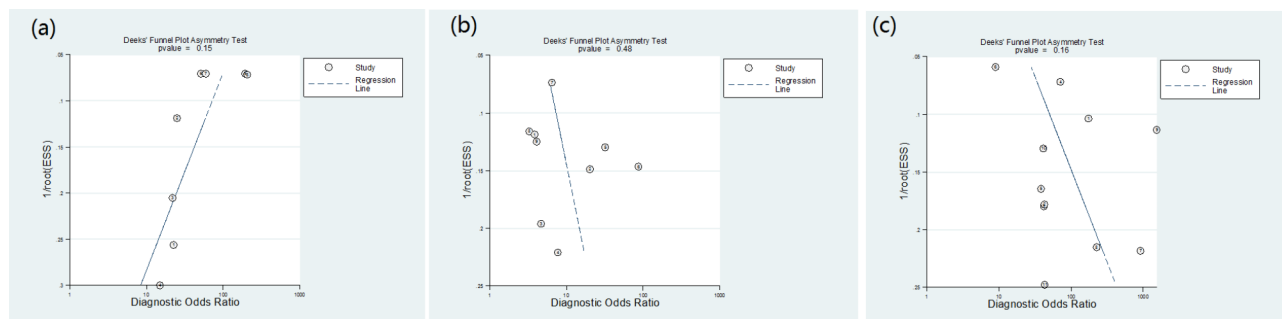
Funnel plot of ^{18}F -PSMA-1007 PET/CT (a), ^{18}F -FDG PET/CT (b) and ^{68}Ga -PSMA PET/CT (c)
